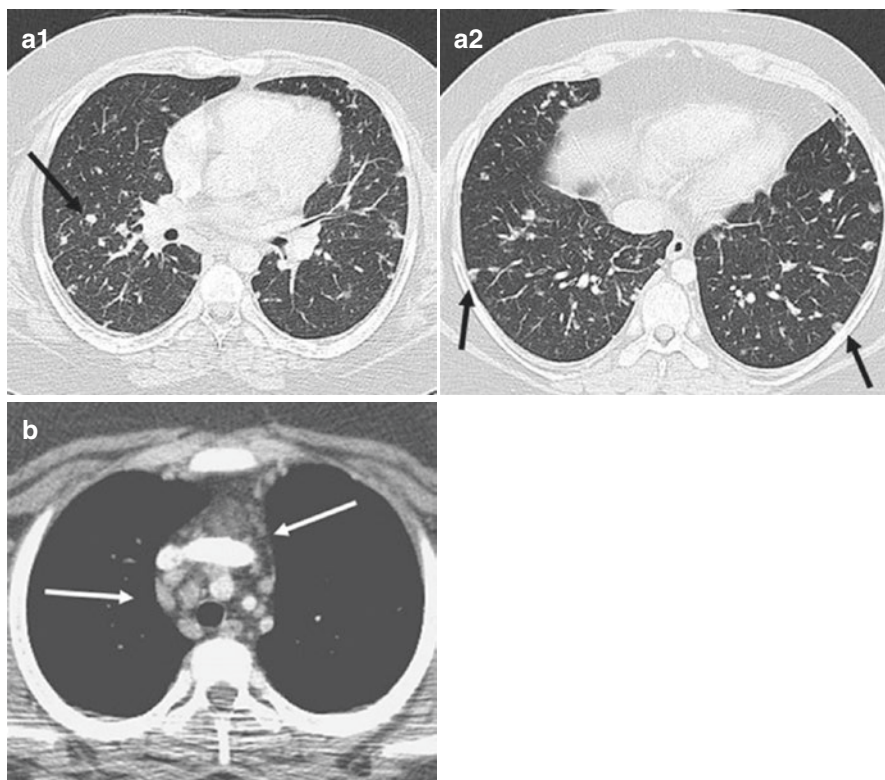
CT (a) reveals multiple pulmonary parenchymal nodules and small mediastinal lymph nodes. (b) Biopsy of the parenchymal nodules confirmed PTLD. (Courtesy of Dr. David Manson, Hospital for Sick Children, Toronto)
